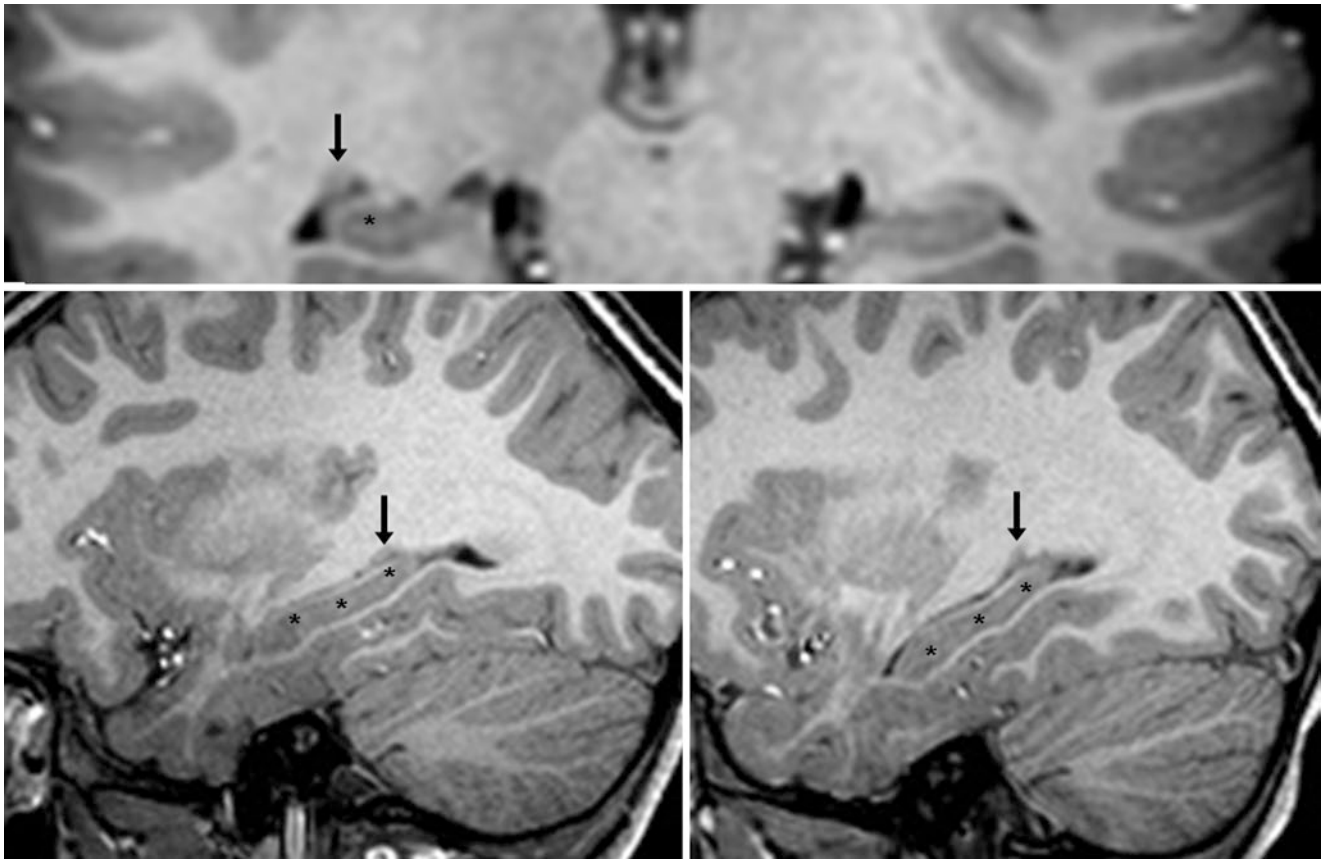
A 6 year old with headaches had a negative 3 T MRI evaluation. On coronal T1WI (*top*), a nodular focus of gray matter signal (*arrows*) is noted just superior to the posterior portion of the hippocampus (* denotes the dentate gyrus within the center of the hippocampus).
